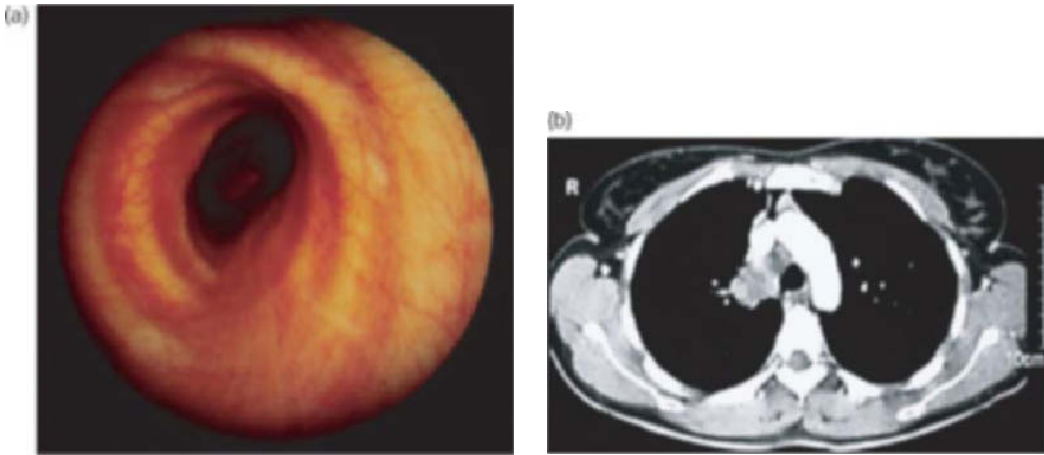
Compression of the trachea by tumor (a). The corresponding CT scan shows the tumor adjacent to the trachea and cannot be separated from the tracheal wall due to extinction of the mediastinal fat (b).
